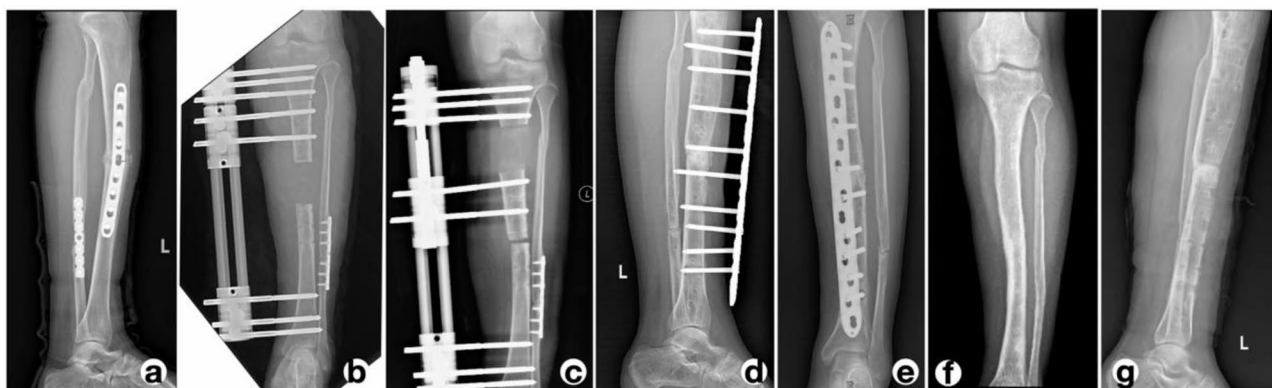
A 42-year-old male with a left tibial bone defect caused by FRI was managed by an LCP as a sequential external fixator following the distraction phase. (a) X-ray of left tibia before Ilizarov bone transport surgery. (b) DS after radical debridement was approximately 6.5 cm. (c) The termination of the distraction phase and docking site was connected in the 9th postoperative week. (d, e) LCP as a sequential external fixator following the distraction phase, with an interval of 3.9 weeks. (f, g) Satisfactory bone result after 10.3 postoperative months
